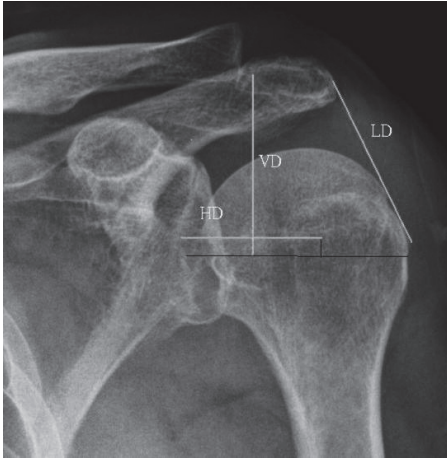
Radiographic examination of shoulder subluxation. The lateral distance (LD) was measured from the lateral border of the acromion to the greater tuberosity of the humerus, vertical distance (VD) was measured from the inferior acromial point to the central point of the humerus head, and the horizontal distance (HD) was measured from the central point of the glenoid fossa to the central point of the humerus head.
